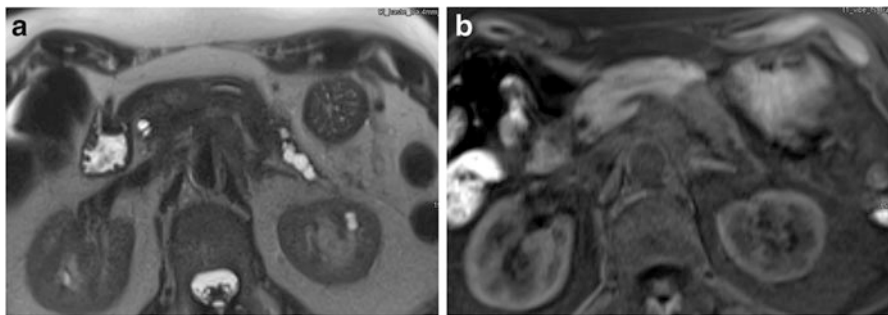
MRI of a small indeterminate lesion. (a) Axial plane in a HASTE sequence (special high contrast and high spatial resolution water-weighted sequence): abrupt duct occlusion secondary to a small lesion of the tail of the pancreas; (b) axial plane noncontrast T1 gradient echo sequence showing a very high parenchymal contrast difference between tumors and normal pancreatic tissue
